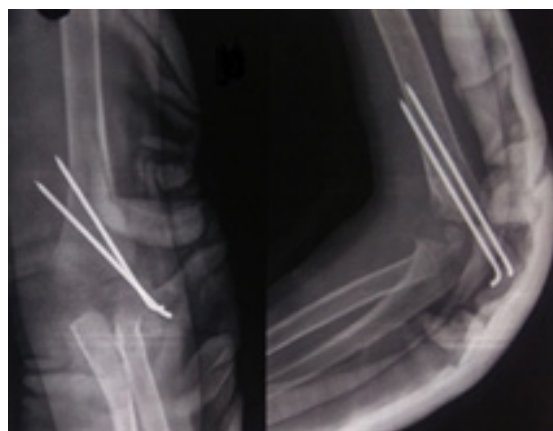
X-ray Ap and lateral view on 1st post operative day
